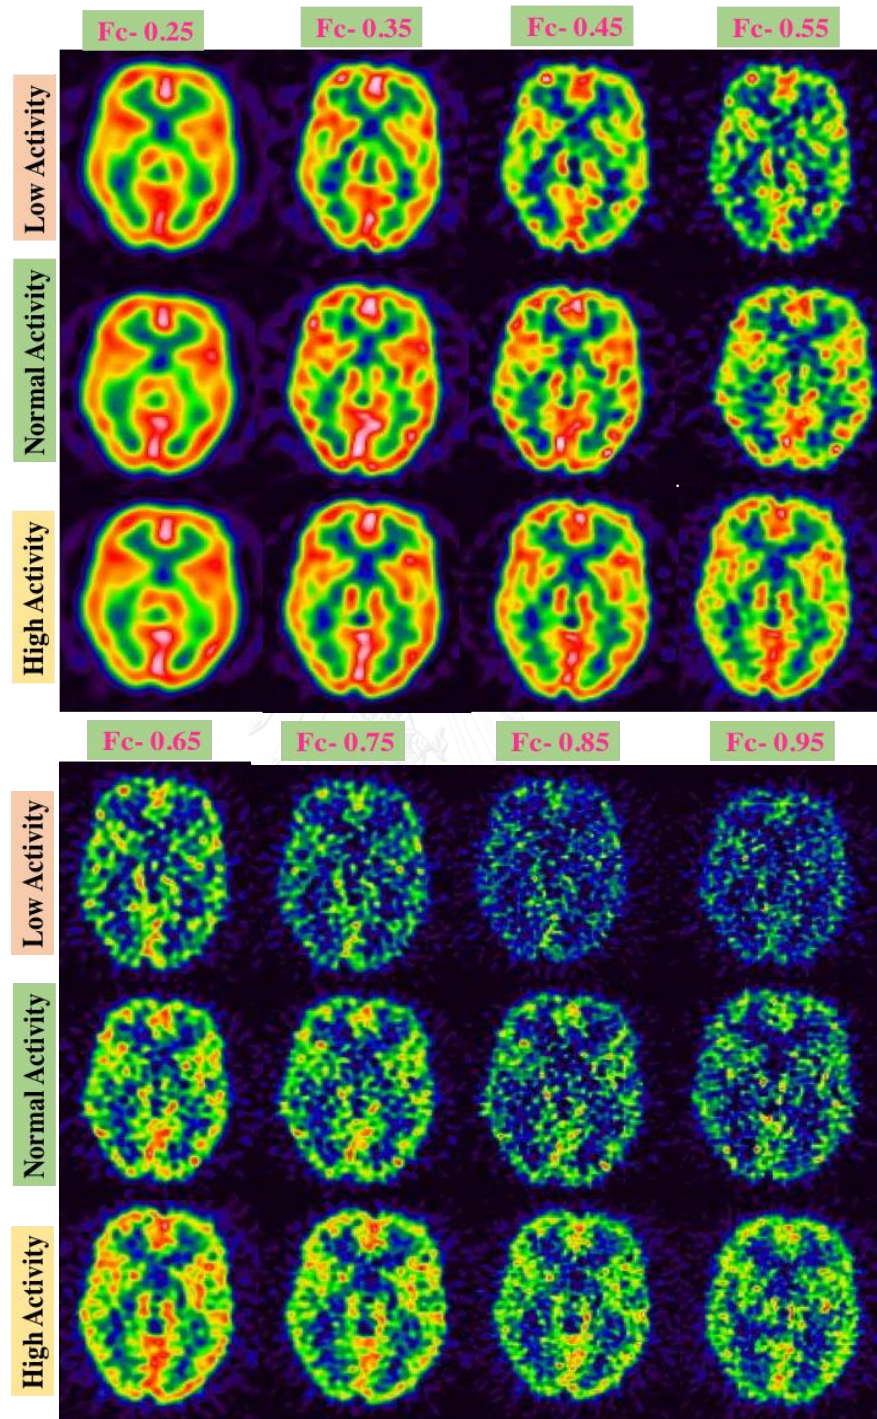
Brain SPECT images by varying cut-off frequencies of each activity concentration in FBP method
